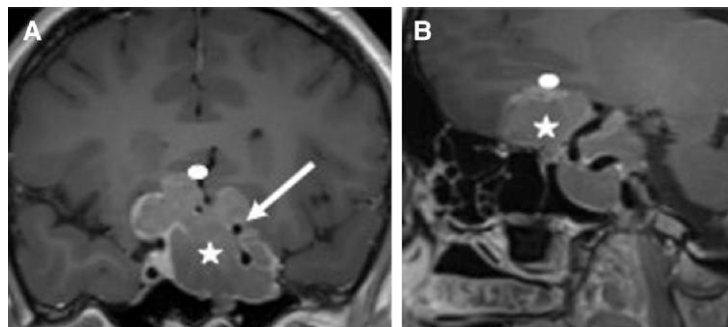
(A) Coronal and (B) sagittal views of MRI scan of the brain performed with a pituitary protocol, demonstrating a giant pituitary adenoma (stars) invading the cavernous sinus (arrow) and compressing the optic chiasm (ovals).
